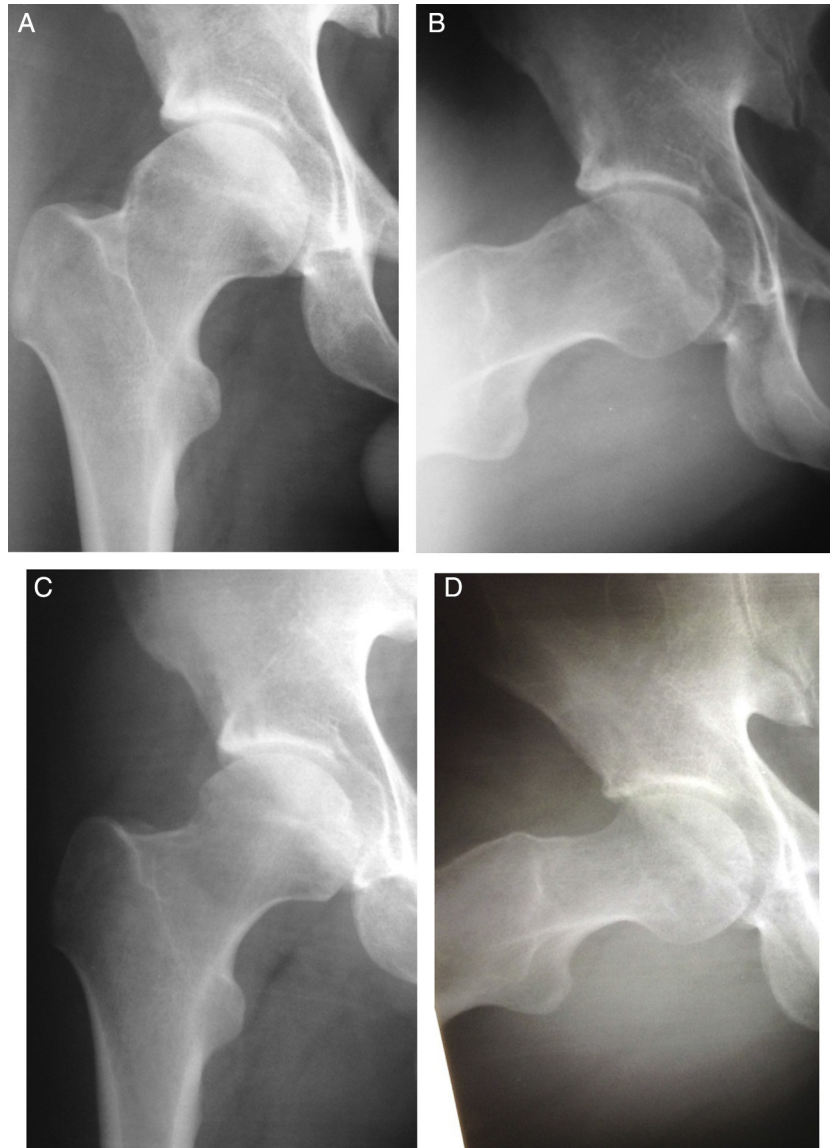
Male patient aged 37 years. Internal rotation of 0°. (A, B) Preoperative radiographs showing FAI of mixed type, θ_{CE} : 32°, θ_{α} : 78° and crossing of the acetabular lines. (C, D) Radiographs produced 1 year and 3 months after the operation, in which femoral osteochondroplasty had been performed in association with labral refixation. The patient evolved well, to internal rotation of 15°, with normalization of θ_{α} .
